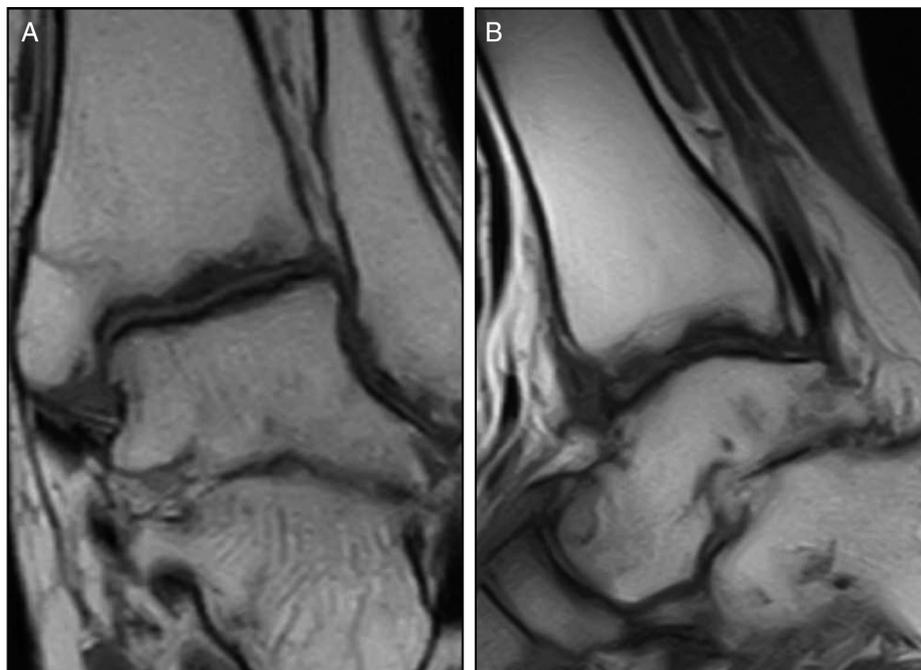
Magnetic resonance imaging scans at 1.5 years postoperatively. (A) Coronal and (B) sagittal magnetic resonance imaging scans revealing that the surface of the talar dome and plafond are covered with newly formed tissue.
